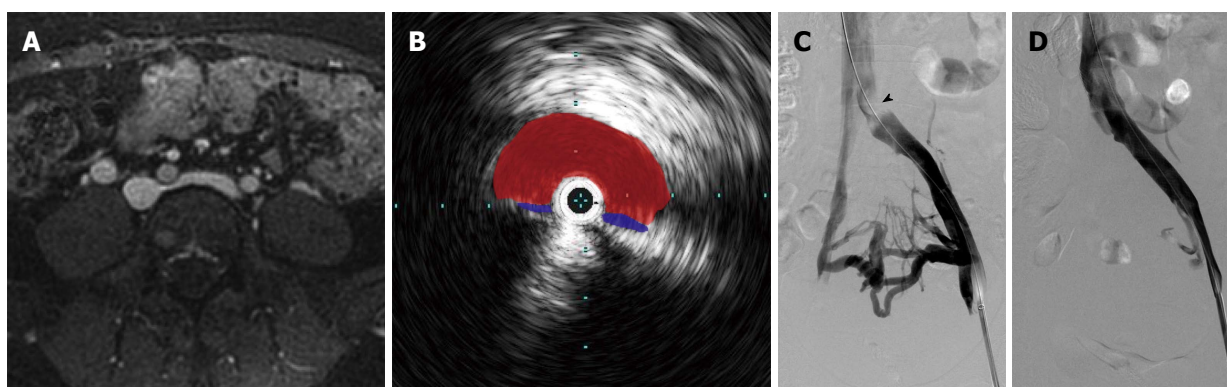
The appearance of May-Thurner syndrome on multiple imaging modalities from a single patient. A: Axial T1 fat-saturated magnetic resonance image following the administration of an intravascular contrast agent demonstrates > 50% narrowing of the left common iliac vein by the overlying right common iliac artery; B: Intravascular ultrasound with the transducer within the left common iliac vein (blue) demonstrates near complete obliteration of the vessel's lumen due to compression by the right common iliac artery (red); C: Digital subtraction angiography with contrast injection from a vascular sheath in the left external iliac vein demonstrates an obliquely oriented silhouette of the right common iliac artery compressing the left common iliac vein (arrowhead); multiple left-to-right pelvic collaterals are also present, signifying that the compression is hemodynamically significant; D: Following the placement of an uncovered stent, the compression is resolved, and there is no longer filling of the cross-pelvic collaterals.
